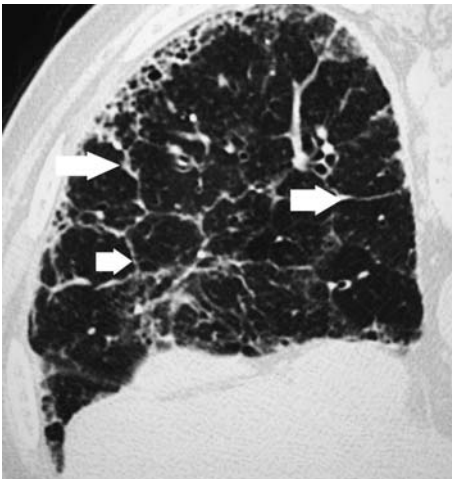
Prone thin-section computed tomography of an asbestos miner with subpleural honeycombing and thickened interlobular septal lines (*arrows*)
